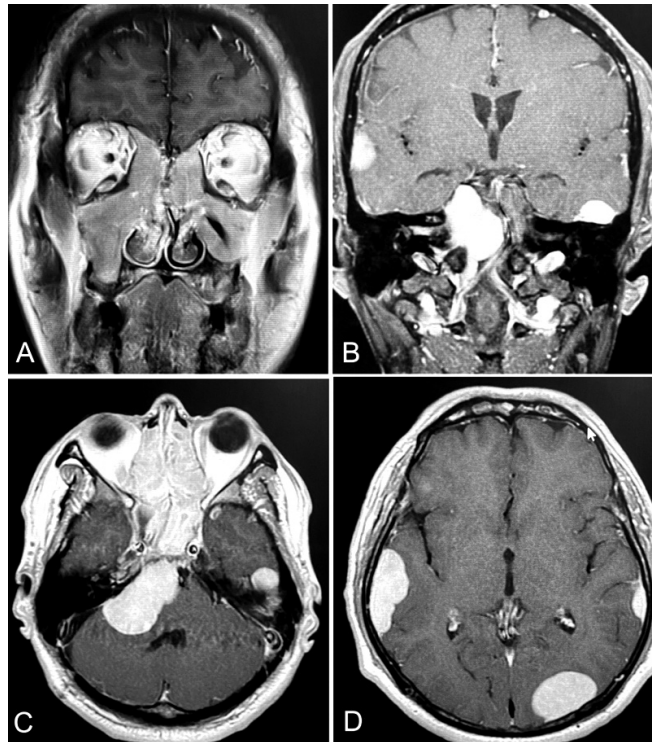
(A) Coronal T1-weighted image showing haziness of mastoid air-cells. (B-D) Postoperative T1-weighted image with Gd-enhanced showing progression of right CPA mass, measured 28.8x3.0x3.5 cm. Other non-resected residual lesions were unchanged as compared to prior study. (B: coronal view, C&D: axial view, respectively).
